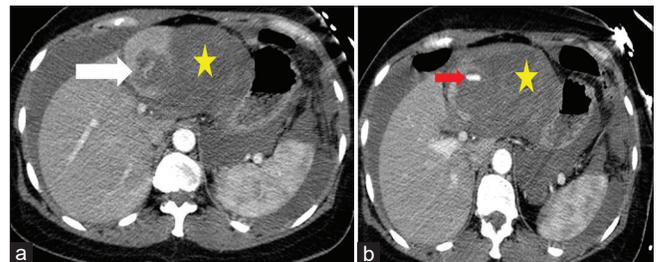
A 53-year-old man with liver cirrhosis. Computed tomography abdomen axial image with IV contrast in a patient with ascites demonstrating the subdivisions of the left subphrenic space. The star indicates the immediate subphrenic space. The white and red arrows indicate the left subhepatic and perisplenic spaces.
